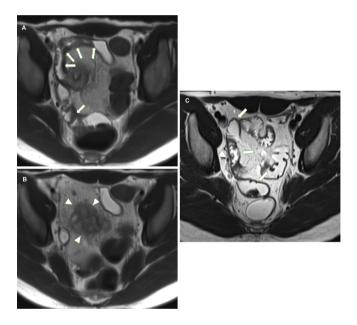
Thickening in multiple loops of distal ileum. A. MRI axial T2 weighted sequence showing thickening in multiple loops of distal ileum (white arrows), in one loop clearly more pronounced on the mesenteric side of the bowel wall, characteristic for Crohn's disease. B. MRI axial T2 weighted sequence demonstrating a pelvic abscess, just superior to the thickened distal ileal loops (white arrowheads). C. 21 months later, MRI axial T2 weighted sequence demonstrating complete resolution of the pelvic abscess. Many of the previously thickened distal loops are now normal (white arrows). MRI: magnetic resonance imaging.
